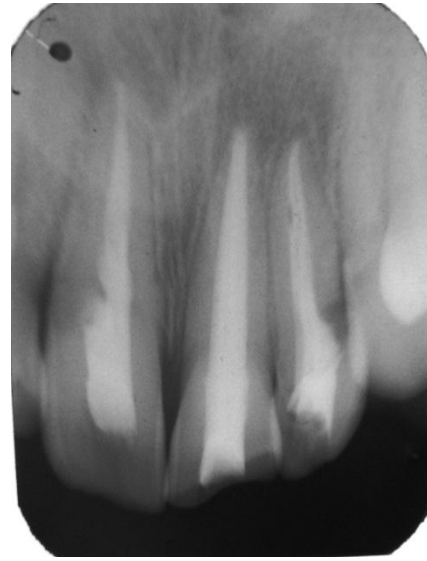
9 months postoperative IOPA showing complete healing of periapical lesion and obturation with 11, 12 and 21
